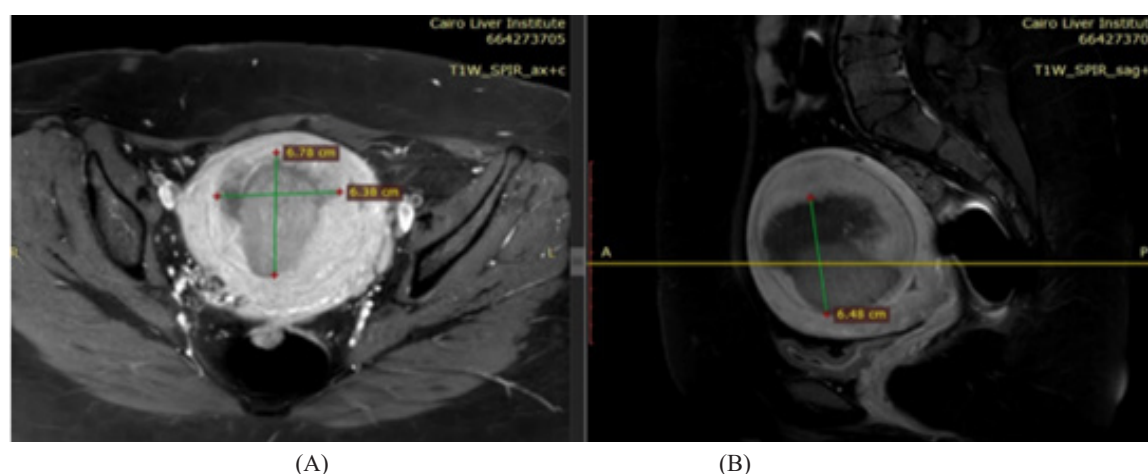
Post MR-HIFU for patient in figure 7. Axial (A) & Sagittal (B) post-contrast T1 MRI images reveal areas of non-enhancement within the former myoma denoting well ablation. Volume of ablated areas after HIFU = 140 cc, calculated NPV = 40%.
